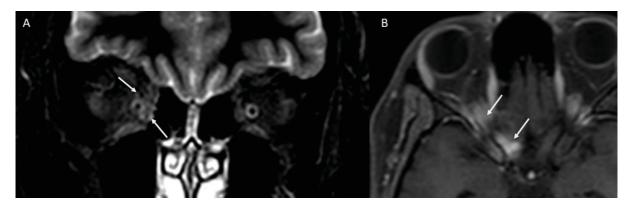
Patient 2. MRI. A. STIR sequence in coronal plane showing hiperintense signal in the orbital fat surrounding optic nerve sheath (arrows). B. Post contrast T1 sequence in axial plane depicting abnormal enhancement adjacent to optic nerve at the level of the orbital apex and optic canal (arrows).
